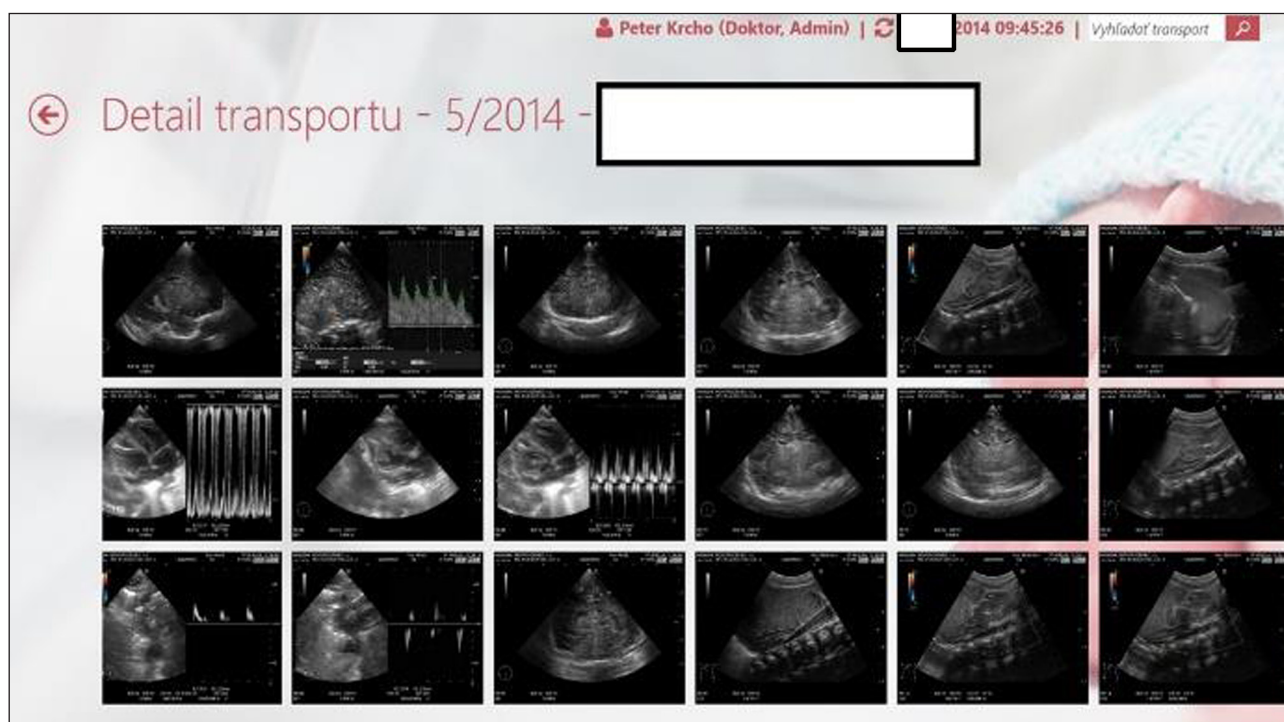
Screen of the recorded ultrasound scans.
